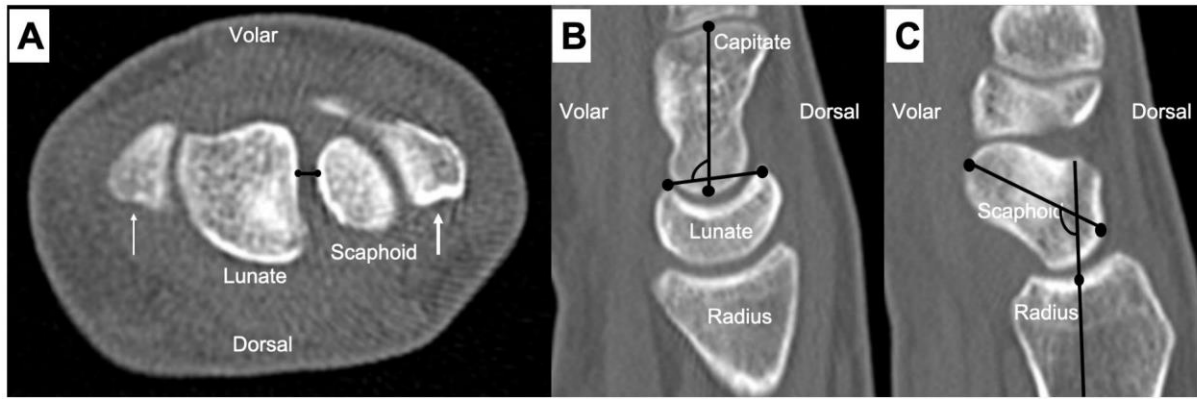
Reference planes and marker position used for performing the gap and angular measurements in the CT multiplanar images.
